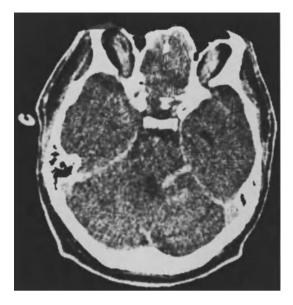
Contrast-enhanced CT scan. Very typical picture of a venous angioma, showing linear and nodular enhancement in the right middle cerebellar peduncle
